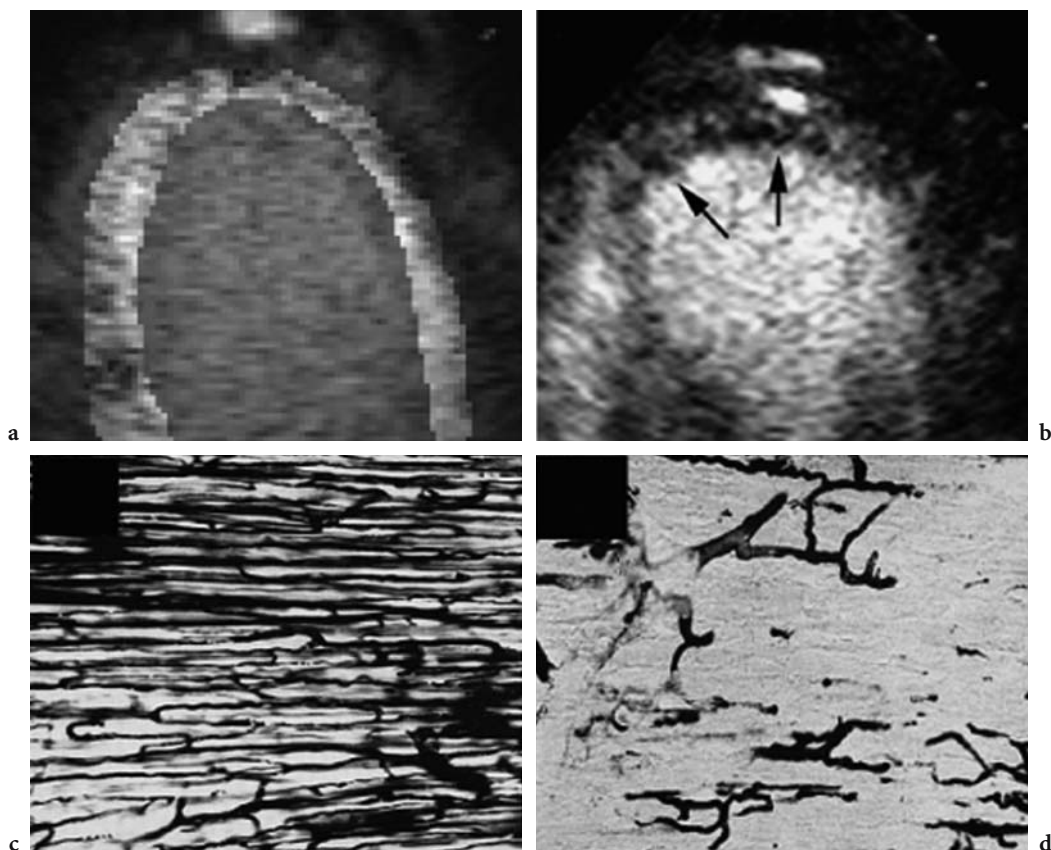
Contrast-enhanced apical three-chamber view shows homogeneous myocardial opacification in all perfusion territories (a) representing normal capillary integrity (c). A focal subendocardial perfusion defect in patient with prior apical infarction (b) is seen (arrows) in the presence of capillary damage (d).
